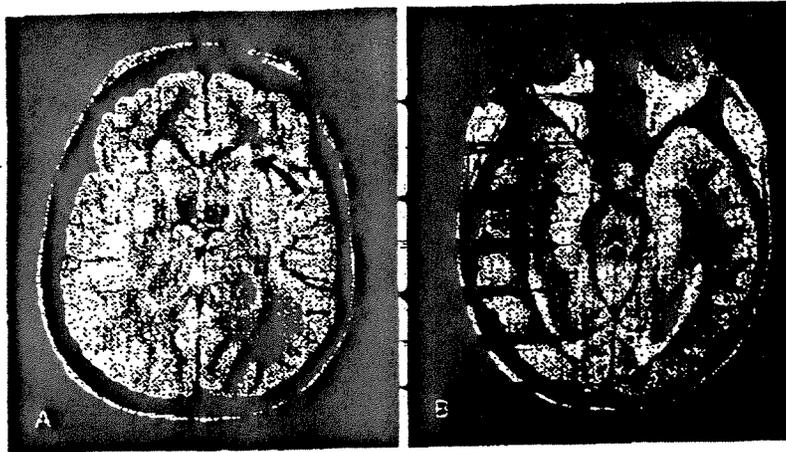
MRI in a case of obstructive hydrocephalus (secondary to a fourth ventricular tumor). Axial images (A and B) with mixed weighting show increased signal surrounding the interstitial CSF in the lateral ventricles (arrow).
